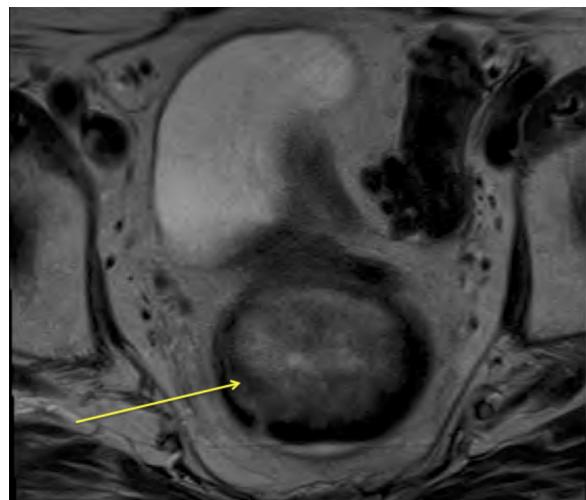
Axial T2 weighted MRI pelvis at the level of the rectum, demonstrating an endoluminal soft tissue rectal mass (Yellow arrow), which has a mixed heterogenous signal.
